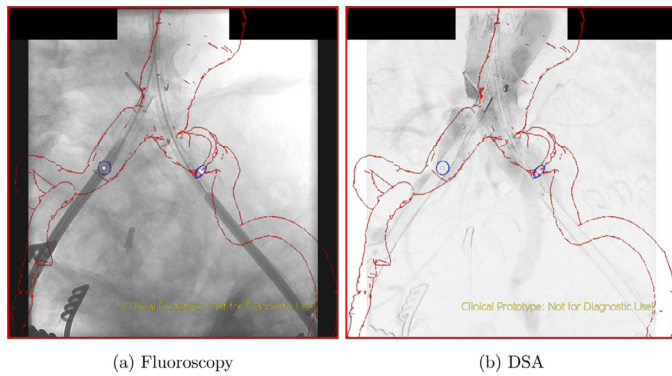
Vascular deformation observed during endovascular repair. The lumen on the pre-operative CT is outlined in red and the ostium are tagged in blue. (For interpretation of the references to colour in this figure legend, the reader is referred to the web version of this article.)
